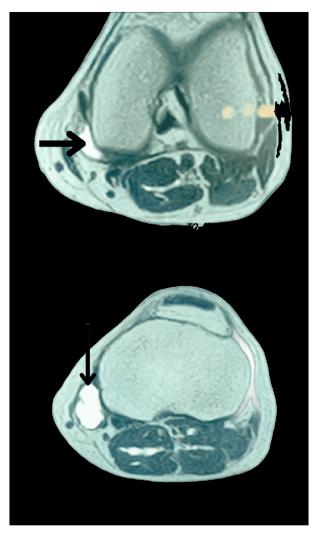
Pre-operative T2 weighted (non-contrast) axial MRI of the left knee joint showing complex medial meniscal tear with parameniscal cyst (black arrow).
